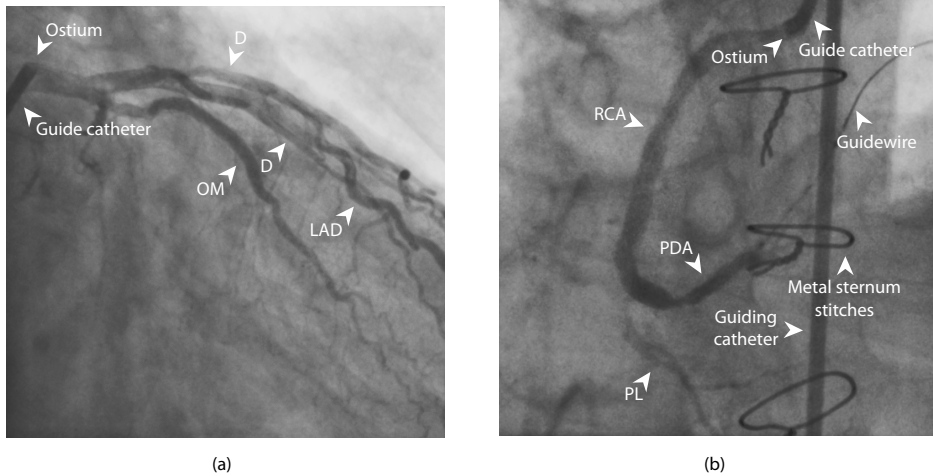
Examples of X-ray coronary angiograms of a (a) left and (b) right coronary tree visualizing the lumen of the coronary arteries by contrast injection and X-ray imaging. Clearly visible are the catheter, the guidewire and some metal sternum stitches. The remaining arrows indicate some of the branches of the coronary tree: RCA = right coronary artery, PDA = posterior descending artery, PL = posterolateral branch, LAD = left anterior descending artery, OM = obtuse marginal branch and D = diagonal branch.
